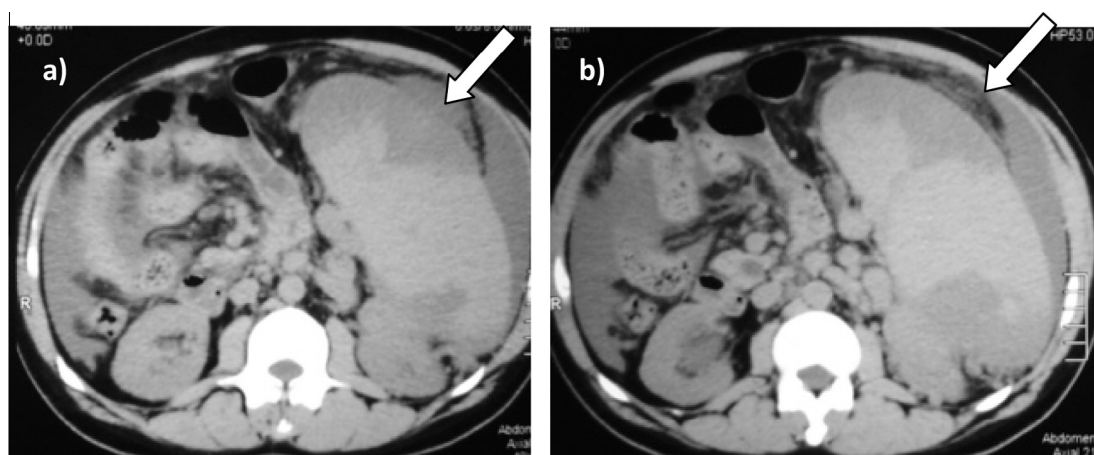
Follow up unenhanced CT scan for the upper abdomen 1 month after the 1st session of PSE showing decreased size of the subcapsular collection. The ascites is still seen.
